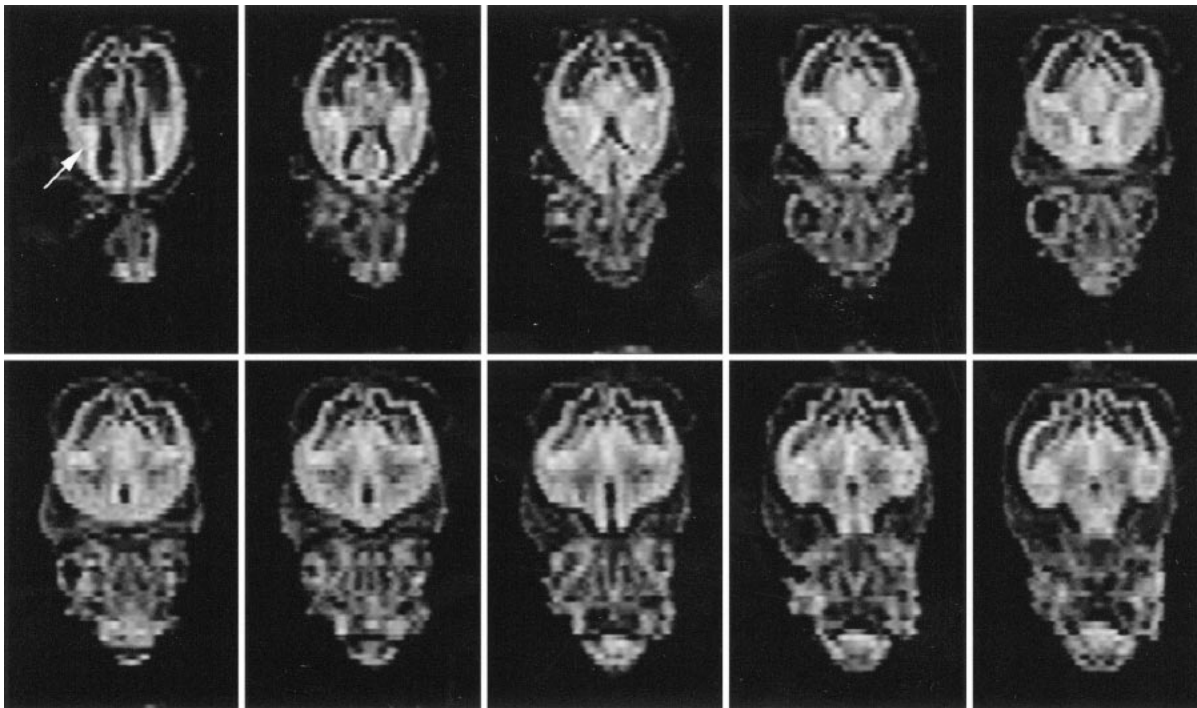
Serial coronal MR images of the fetus at 9 weeks' GA. Note germinal matrix is detected ventrolateral to the lateral ventricles (arrow).
